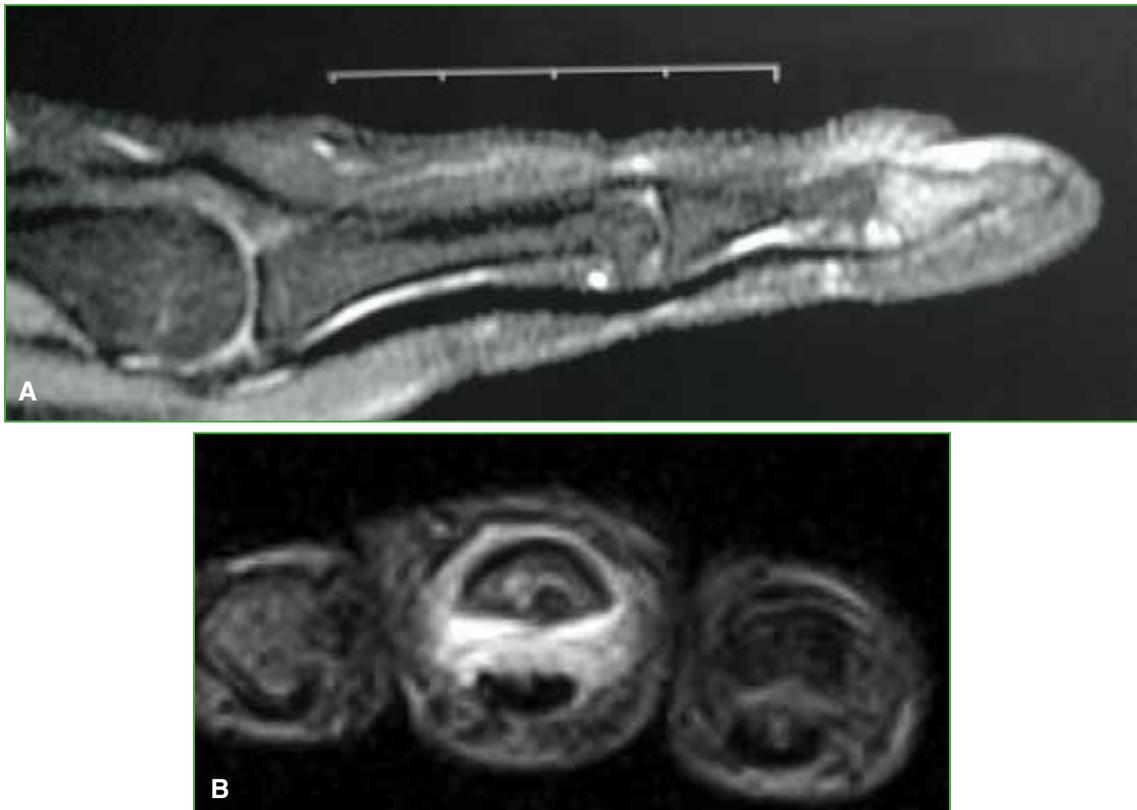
A. Case 1. MRI sagittal section. Hyperintense image (T2-weighted) of the distal phalanx and soft-tissue edema. B. Case 4. MRI-axial section. Notice the significant soft-tissue edema. Nidus may be evidenced in the volar cortical.
